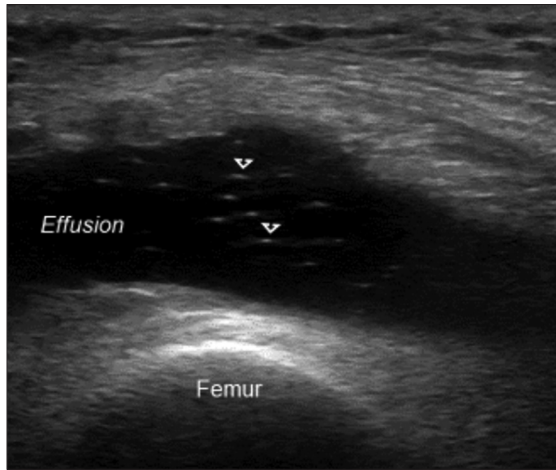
Sonographic image of the suprapatellar pouch in short axis. This picture shows multiple hyperechoic dots within a moderate effusion (“snowstorm”) in a patient with gout after ambulation
